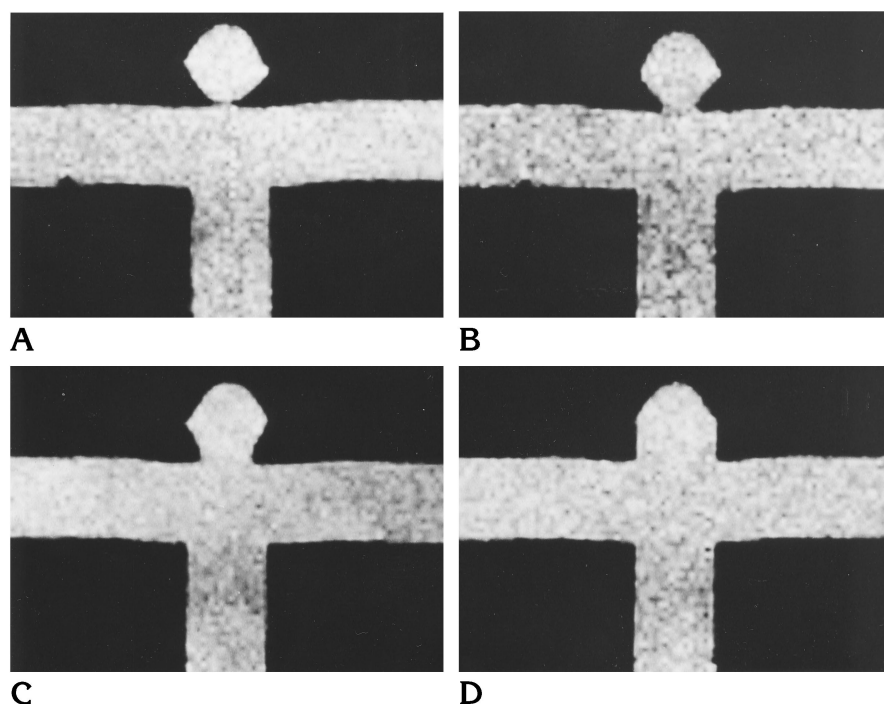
Spin-echo T1-weighted images (300/15) of terminal saccular aneurysm models with fluid but without active flow. The height and fundus diameter of the models were 10 mm; the neck diameters were 2.5 mm (A), 5.0 mm (B), 7.5 mm (C), and 10.0 mm (D).
